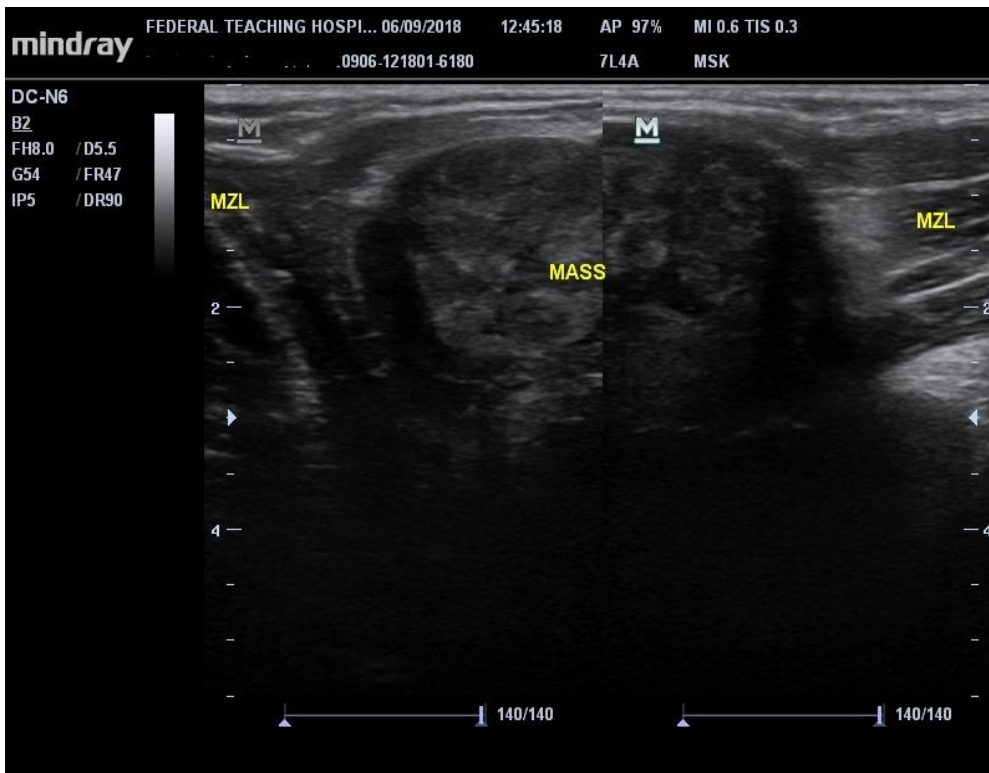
Longitudinal ultrasonographic image of the elbow joint showing a well-defined heterogeneously echogenic mass displacing the adjacent muscles posteriorly.
